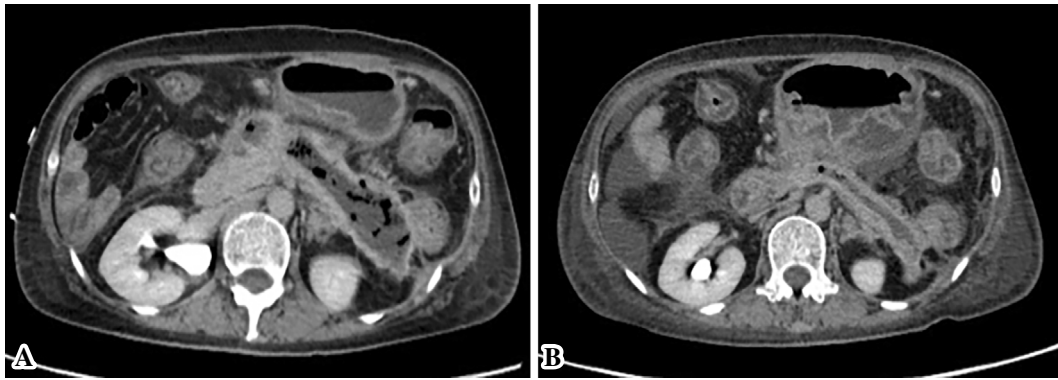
WON gradually decreased in size during recovery stage without intervention. A: Follow up CT in the hospital day 87. Follow up CT in the hospital day 130.
